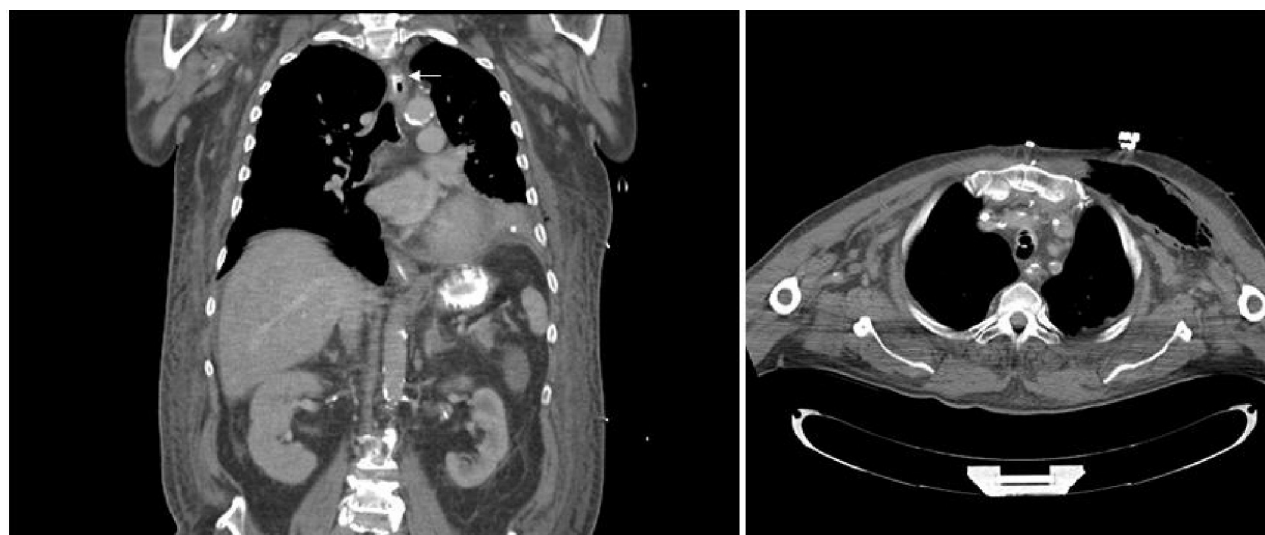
Thoracic computed tomographic scan showing the endoclip closure of the esophageal leak after central venous catheter insertion (left, arrow) and the mediastinal shift (right).
